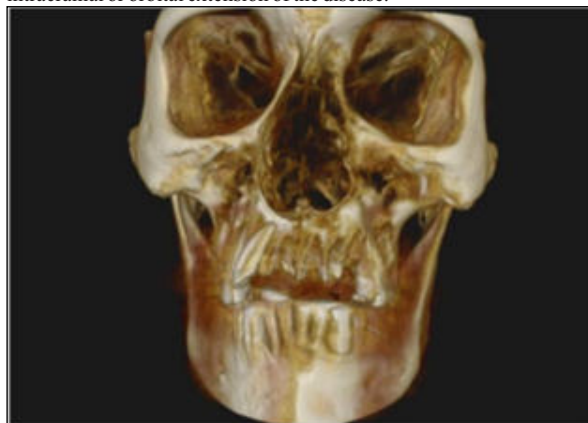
CBCT Revealed Erosion Of The Maxillary Bone With “moth Eaten” Appearance In Three Dimensional View (14).
